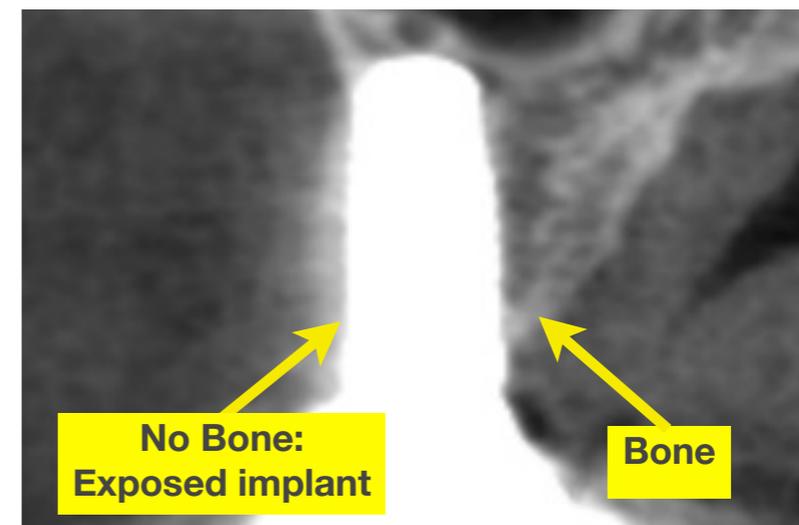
Implant is shown in a cross section of a CT scan: The selected implant was too wide and placed in insufficient bone resulting in exposed implant surface.
